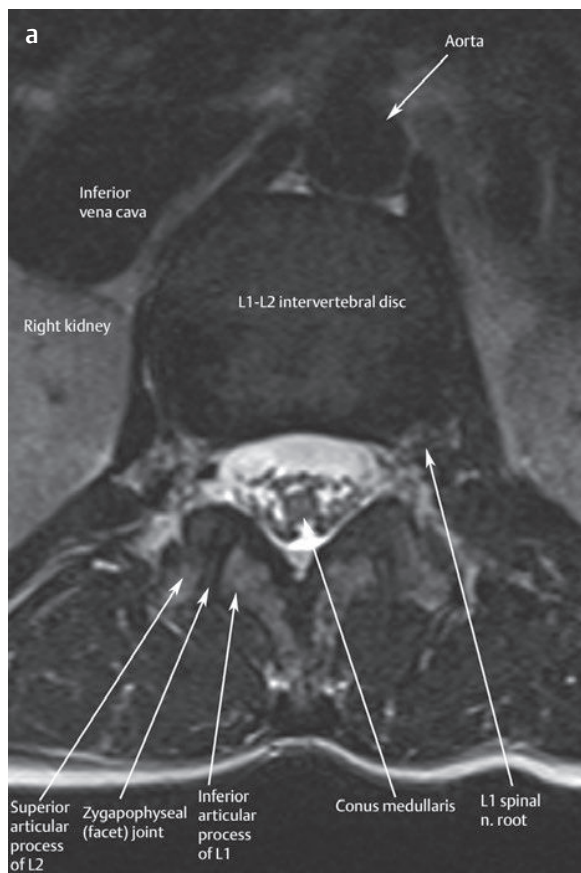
This (a) axial T2-weighted image and (b) artist's sketch of the normal anatomic location of the paraspinal muscles and other neurovascular structures. These views at the level of the L1-L2 intervertebral disc show the conus medullaris and the L1 spinal nerve root, as well as the superior and inferior articular processes of the L1-L2 facet joint.[†]
